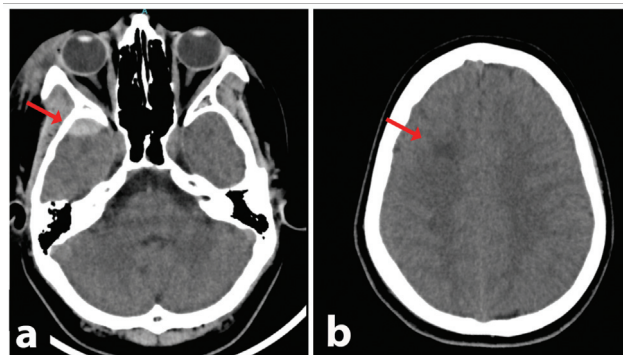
Initial head computed tomography scan, performed on admission. (a) Axial plane image, showing a small (8 mm) epidural hematoma in the middle cranial fossa on the right side (red arrow). (b) Axial plane image, showing a small, nonspecific, hypodense subcortical lesion in the right frontal lobe (red arrow). Aside from the aforementioned features, no alterations could be seen.
